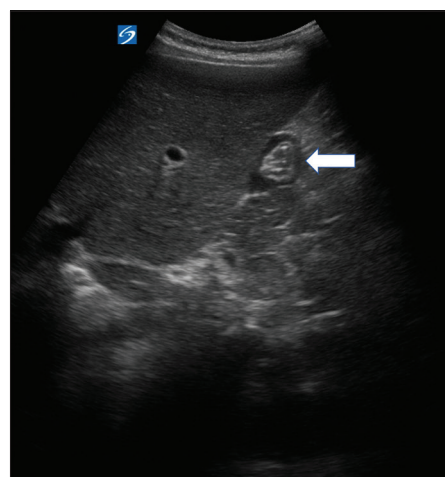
Repeat gastric point-of-care ultrasound performed 2 hours later showing a small gastric antrum with minimal echogenic fluid, demonstrating a bull's eye sign (arrow)
